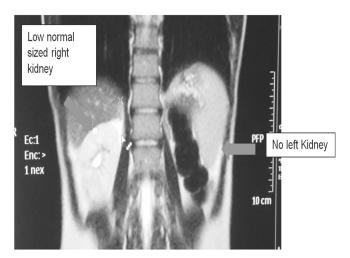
MRI: no normal left kidney, low normal sized right kidney
